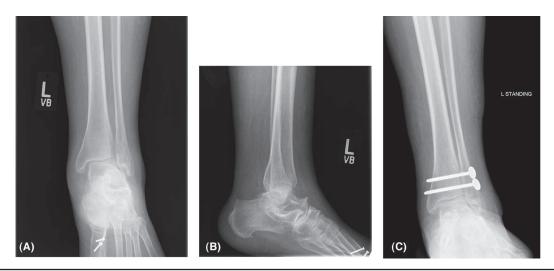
Preoperative X-rays (views A, B) of AP/Lateral of the ankle depicting Maisonneuve fracture. Note diastasis of the tibiofibular clear space to be >5mm. View C shows a postoperative X-ray of ORIF after stabilization of syndesmotic disruption and Maisonneuve fracture. Also note previous ORIF of great toe. X-rays courtesy of Johnny Lin, MD, Midwest Orthopaedics at Rush Chicago, IL. Used with permission.
